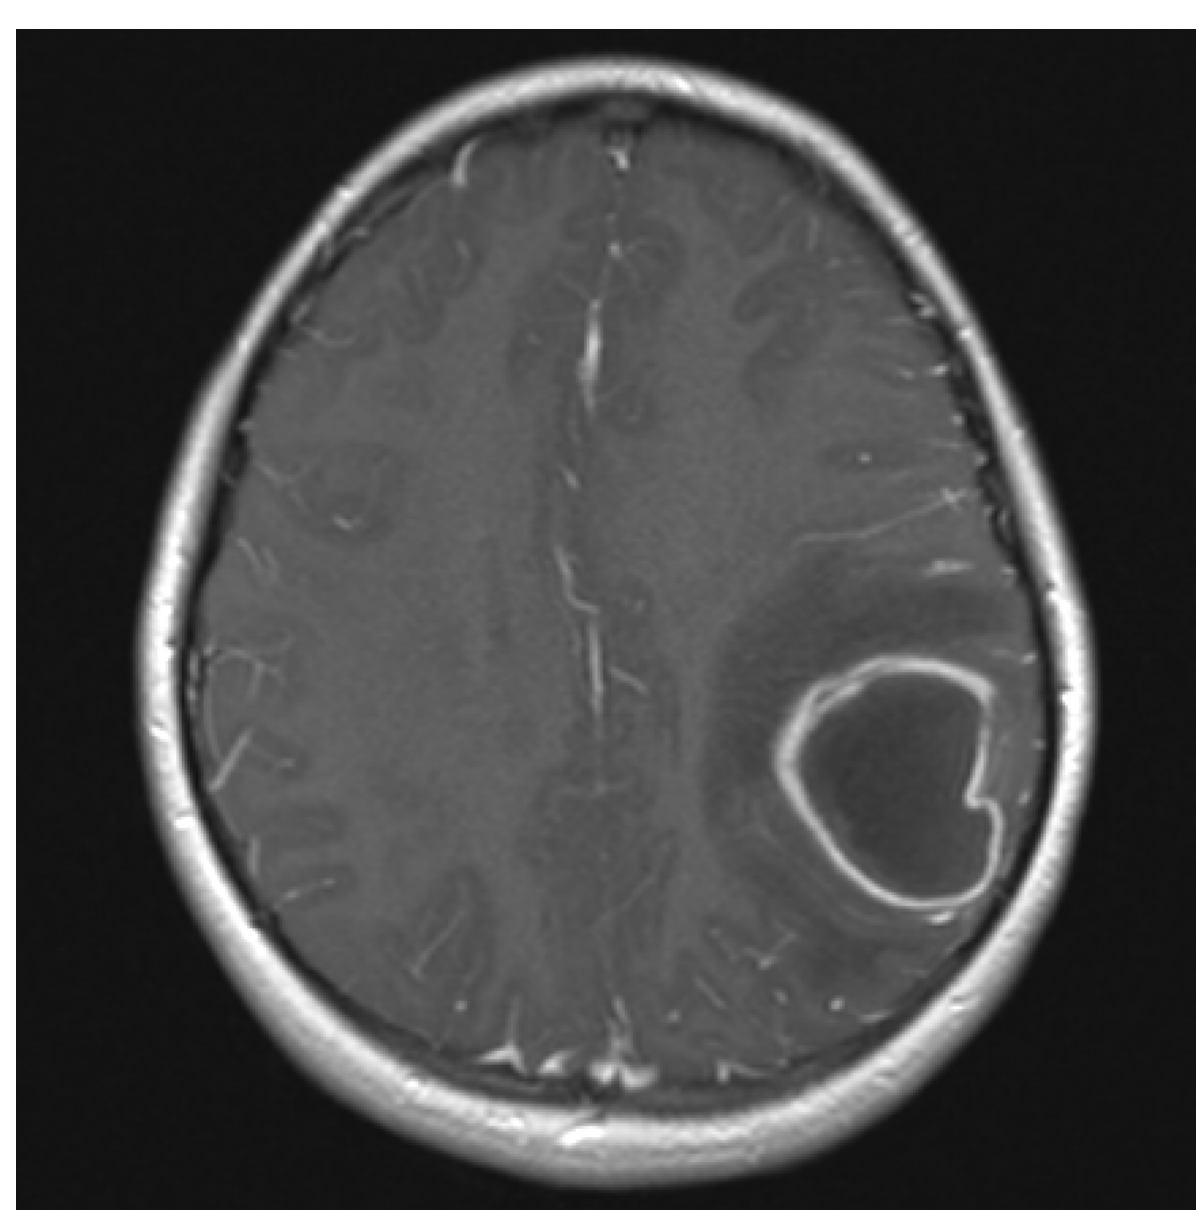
T1 post-contrast MRI Brain showing abscess
